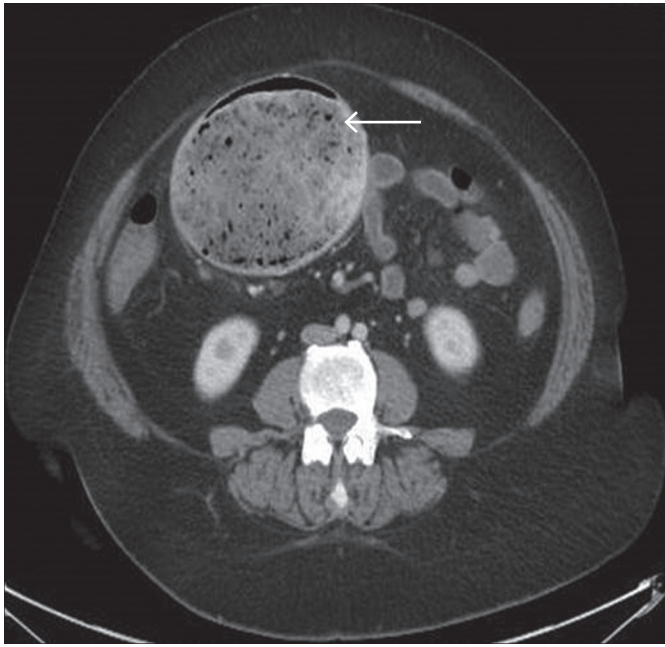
Computed tomography image suggestive of a 9–10 cm bezoar (white arrow) in the mid small bowel.
